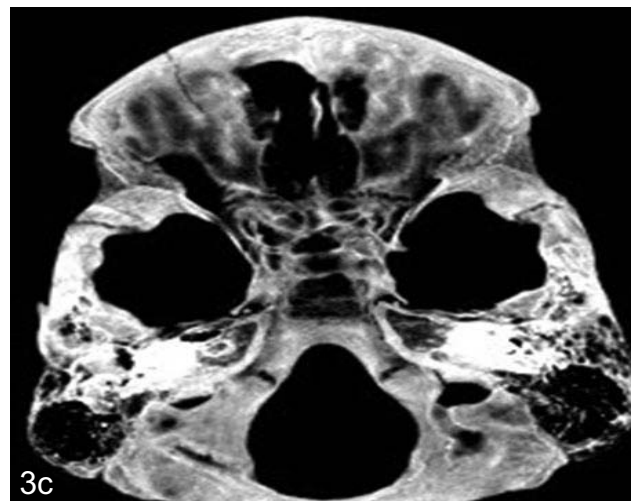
represent easily missed craniofacial fractures involving orbits. 3a: Coronal CT shows left orbit floor fracture which was overlooked when scan was reviewed on axial images only. 3b: Coronal CT head in bone window algorithm shoes left parietal bone fracture, however subtle hairline fracture of right orbit roof was missed which becomes evident using MPR mip images as seen in 3c.
